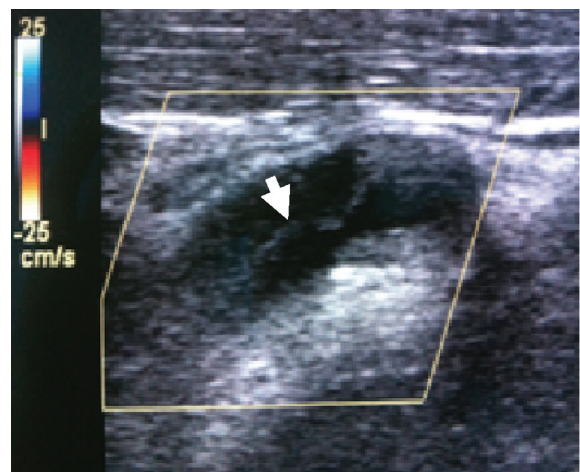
Duplex ultrasonography showing intimal flap (arrow) at cervical segment (C1) in left internal carotid arterial dissection.
